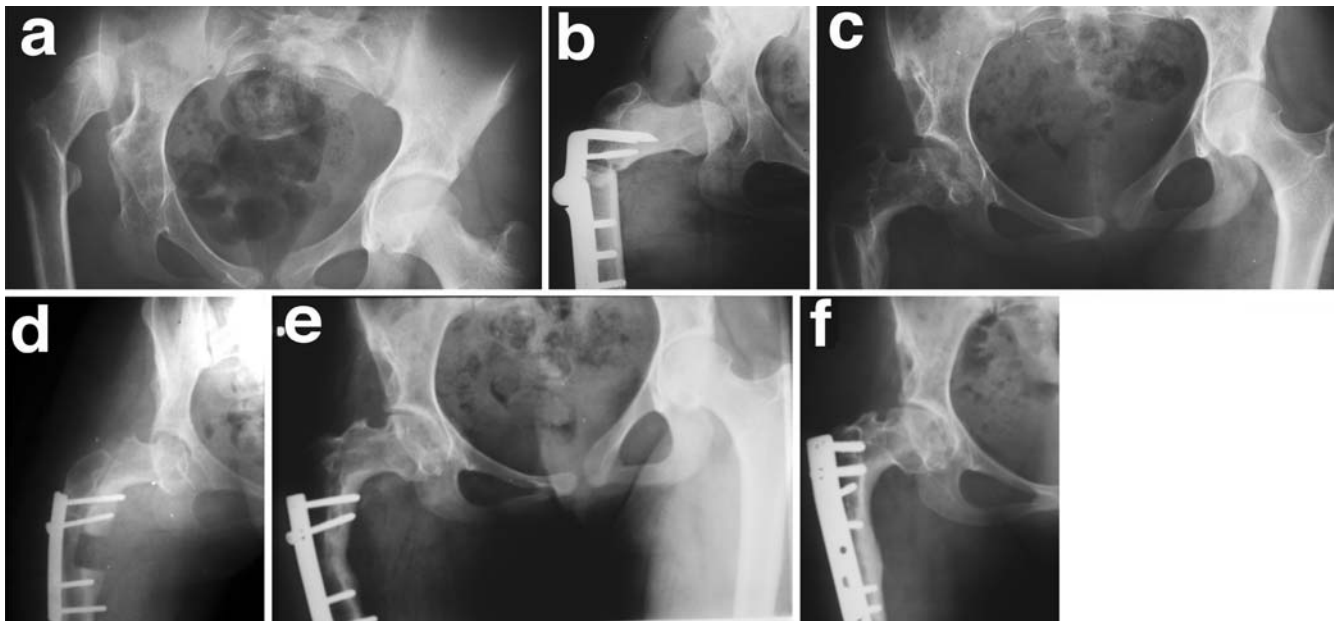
a Anteroposterior radiograph of the pelvis shows high dislocation of the right hip. b Reduction of the hip accompanied with subtrochanteric derotational osteotomy. c Good reduction is shown but the femoral head and neck are in varus
